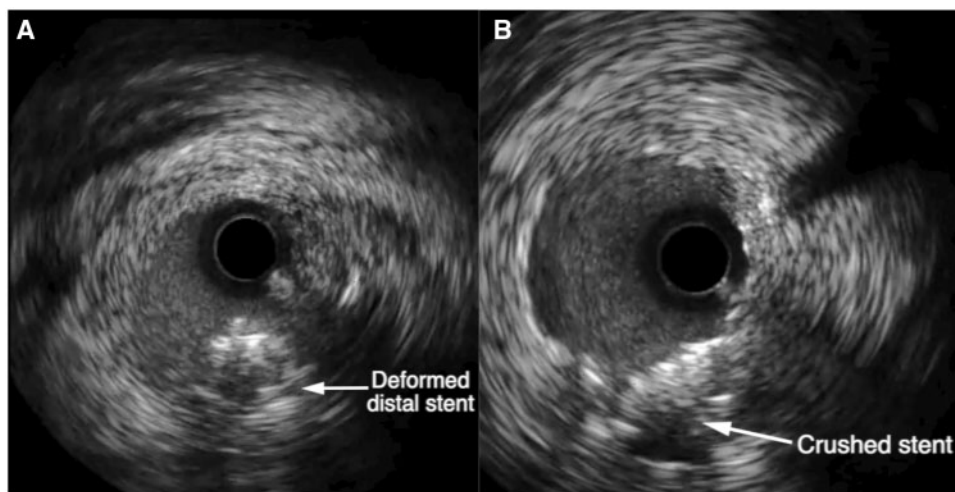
Intravascular ultrasound, showing deformed stent in (A), and after crushing of deformed stent and placement of new stent in (B).
